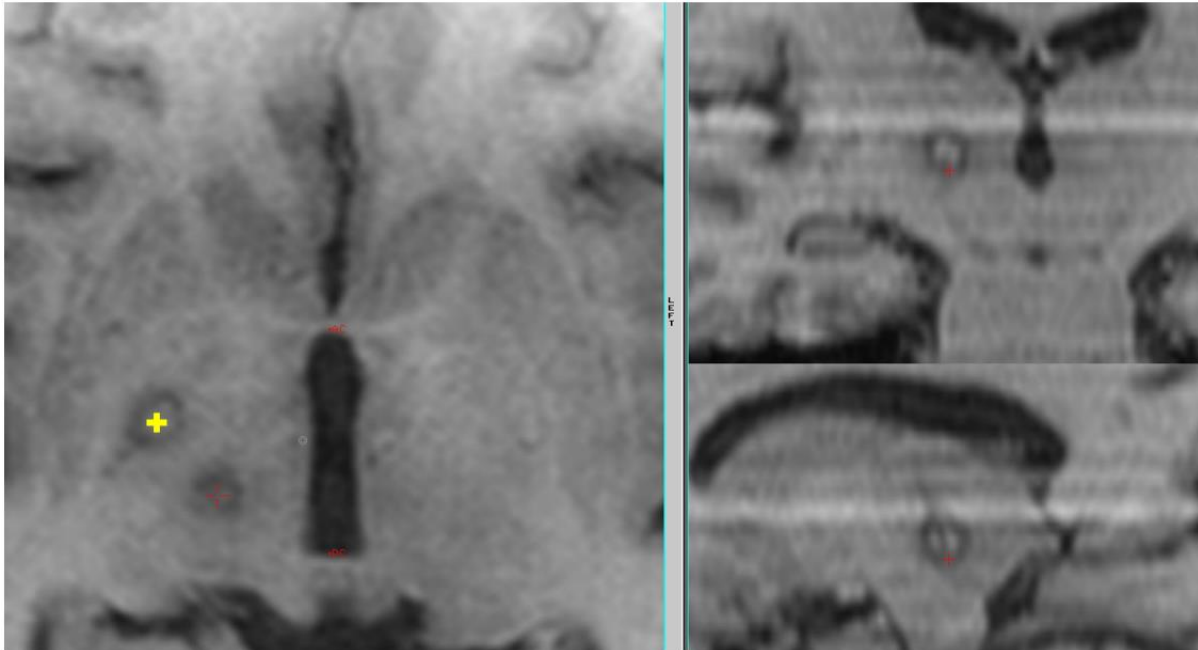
Postoperative MRI T1: Hyperintense right vim lesioning (red cross). a. axial at zero level, b. coronal and c. sagittal plane. Also appear upper limit of Gpi lesion (yellow cross)
